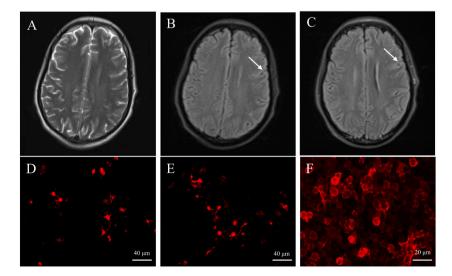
Cranial magnetic resonance imaging (plain scan + enhanced) and detection of Anti-NMDAR and Anti-IgLON5 antibodies at admission: A. plain T2WI sequence, B. plain T2WI-FLAIR sequence: shows slight swelling of the left frontal lobe parenchyma (white arrow). C. enhanced T2WI-FLAIR sequence: slight enhancement of the left frontoparietal leptomeningeal membrane (white arrow); D. Anti-NMDAR antibody in serum (titer 1:10), Scale bars = 40 μ m; E. Anti-NMDAR antibody in CSF (titer 1:10), Scale bars = 40 μ m; F. Anti-IgLON5 antibody in serum (titer 1:30), Scale bars = 20 μ m.
